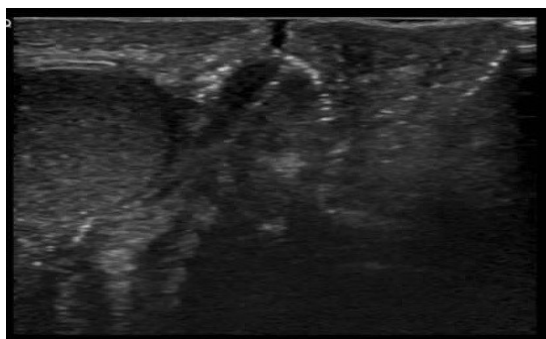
Transverse sonographic image through the midline at the level of the labia demonstrates
